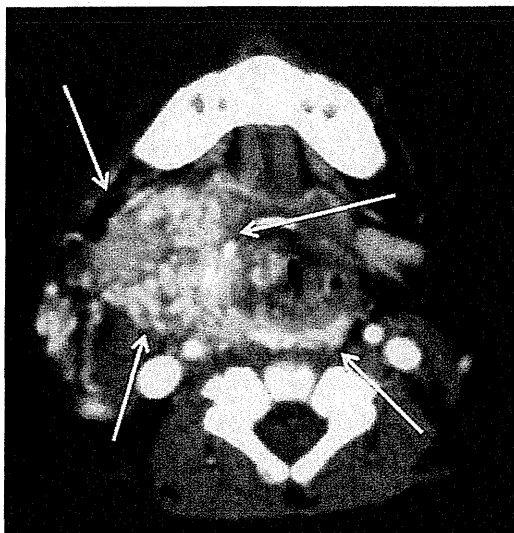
Kaposiform hemangioendothelioma in a 2-month-old boy with Kasabach–Meritt syndrome. Axial contrast-enhanced CT image shows an ill-defined mass with prominent enhancement in the arterial phase (*arrows*)
